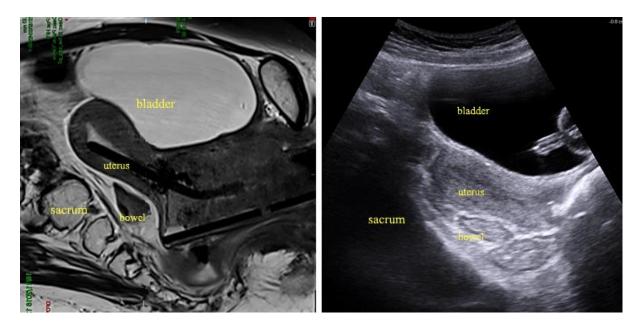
MRI and ultrasound views of uterus and bowel
